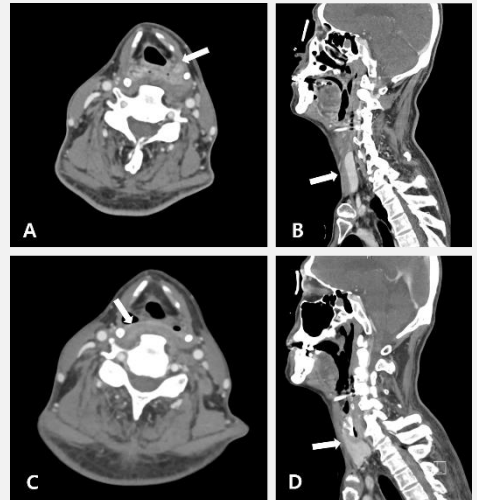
Neck CT showing hypopharynx and retropharyngeal area. (A) Axial image demonstrating hypopharyngitis (arrow). (B) Sagittal image showing hypopharyngitis (arrow). (C) Neck CT of 2-week follow study showing retropharyngeal edema (arrow). (D) Sagittal image of 2-week follow study Neck CT shows progressed state of diffuse retropharyngeal edema (arrow).
